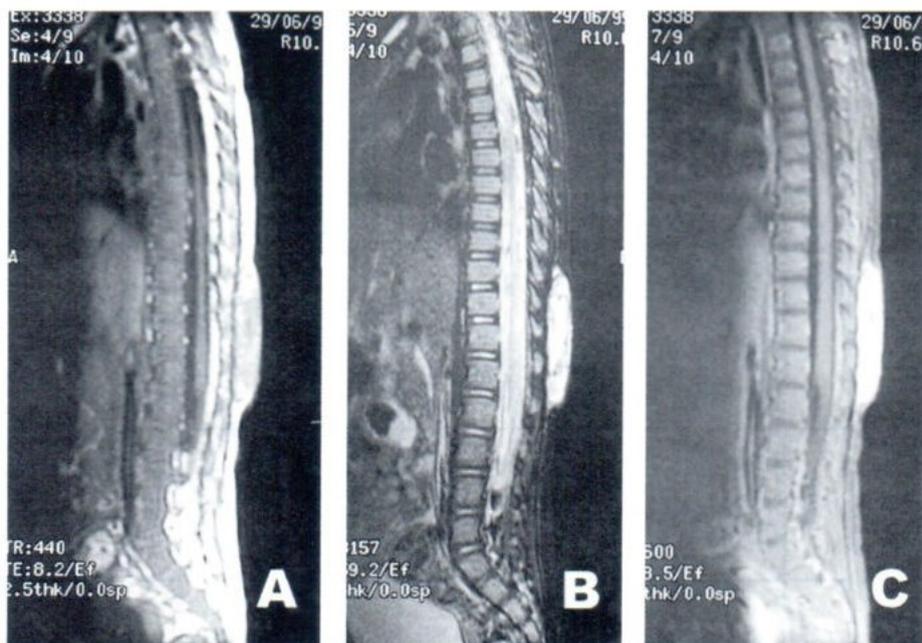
Subcutaneous hemangioma. Sagittal T1-weighted image (A) shows a mass with heterogeneous intensity in the subcutaneous tissue of the back. On sagittal FSET2-weighted image with fat suppression (B), the mass is mixed hyper- and hypointense. On postcontrast sagittal T1-weighted image with fat suppression (C), the mass is markedly enhanced.
